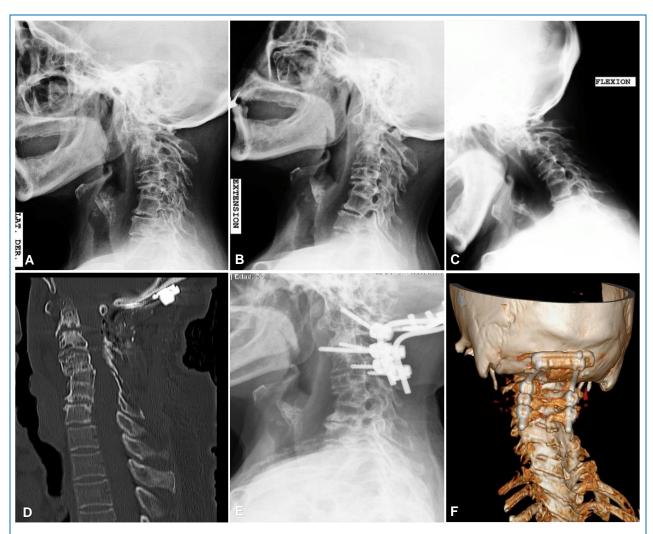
(Case 2): 57-year-old woman with a 30-year history of rheumatoid arthritis, treated pulmonary TB, knee surgery and thoracic surgery. She received therapy with prednisone and methotrexate. The patient presented symptoms of posterior neck pain, brachial paresthesias in the right upper limb. Laboratory tests showed elevated CRP and ESR. (A, B, C) Functional cervical radiography demonstrated the presence of atlantoaxial instability. (D, E, F) The surgery performed was C0-C3 posterior arthrodesis with good clinical evolution on the Ranawat scale, going from grade II to grade I.
